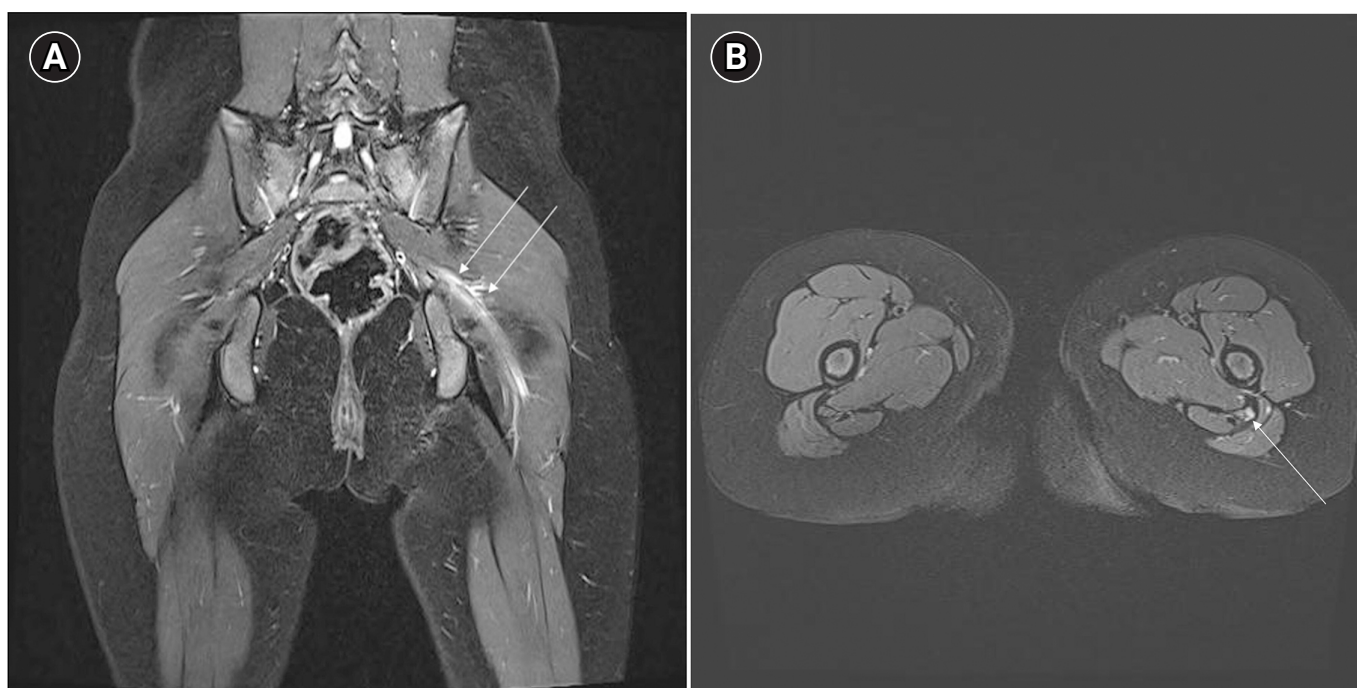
Magnetic resonance imaging of the hip revealed an enlarged diameter of the left sciatic nerve and increased signal intensity in the peroneal portion of the left sciatic nerve on T2-weighted images (arrows). (A) Coronal view. (B) Axial view.
